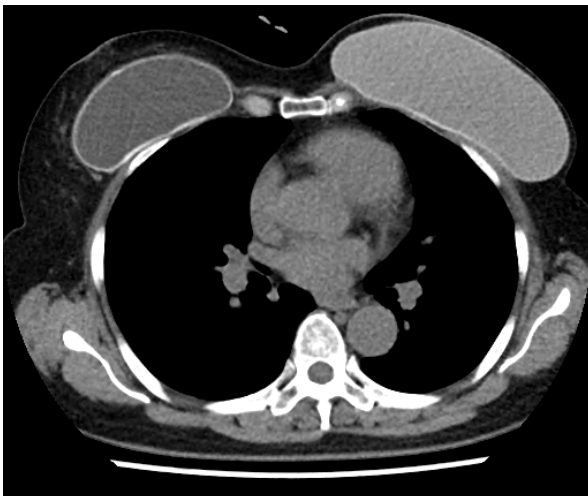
Chest CT showing normally positioned mammoplasty implants in the subareolar region of both breasts, the right breast implant shows water-like attenuation, suggesting a saline-filled bag, while the left breast implant demonstrates relatively higher attenuation, presumed to represent a silicone-filled bag
